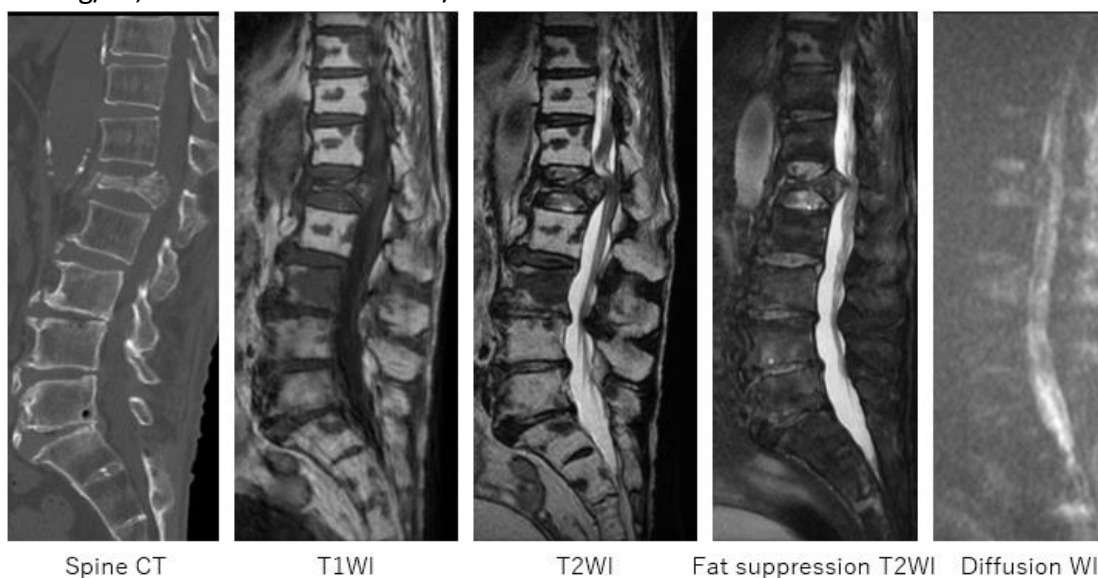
Lumbar spine CT depict L1 compression fracture with calcification. Compression of spinal cord end and equina are depicted on MRI T1WI, T2WI, fat suppression T2WI. Note multiple lesions with low signal intensity on T1WI and T2WI.
